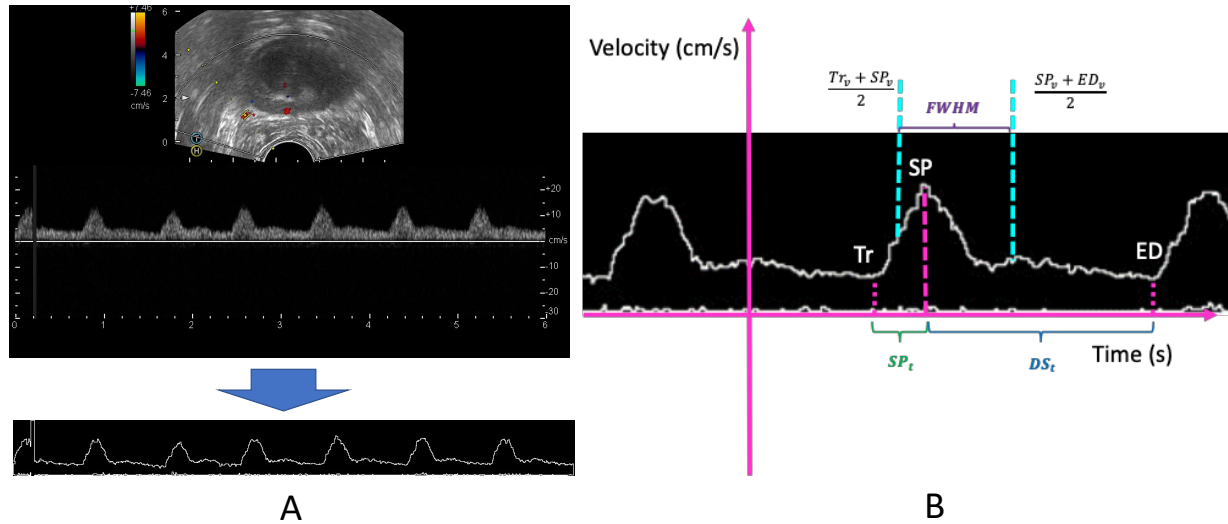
Quantitative analysis of artery flow at neurovascular bundle. (A) Pulse wave extraction from Doppler image using ImageJ. (B) Morphological features are quantified for pulse waveform.
